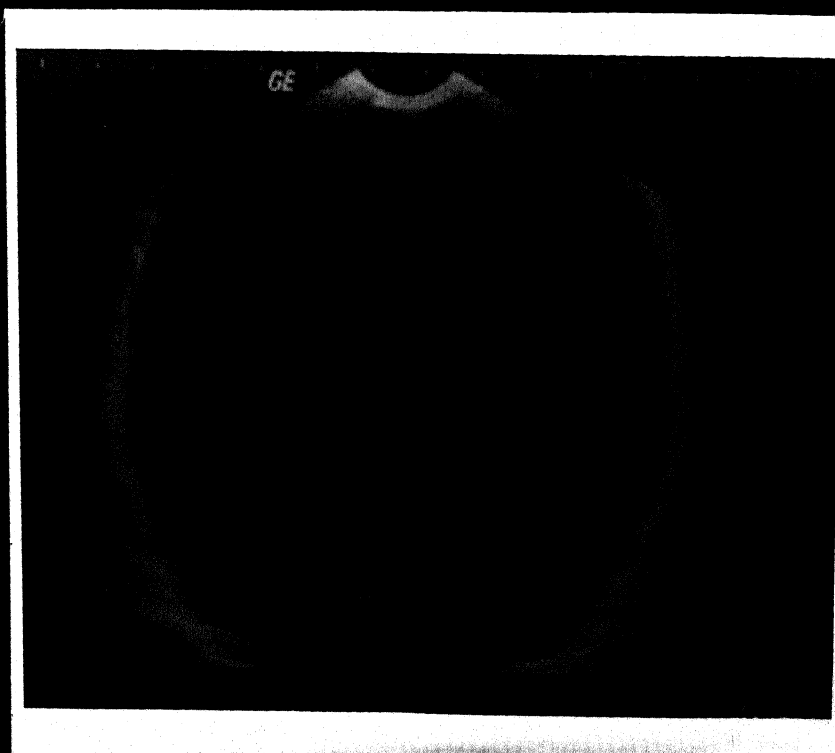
Coronal Cranial Sonogram
